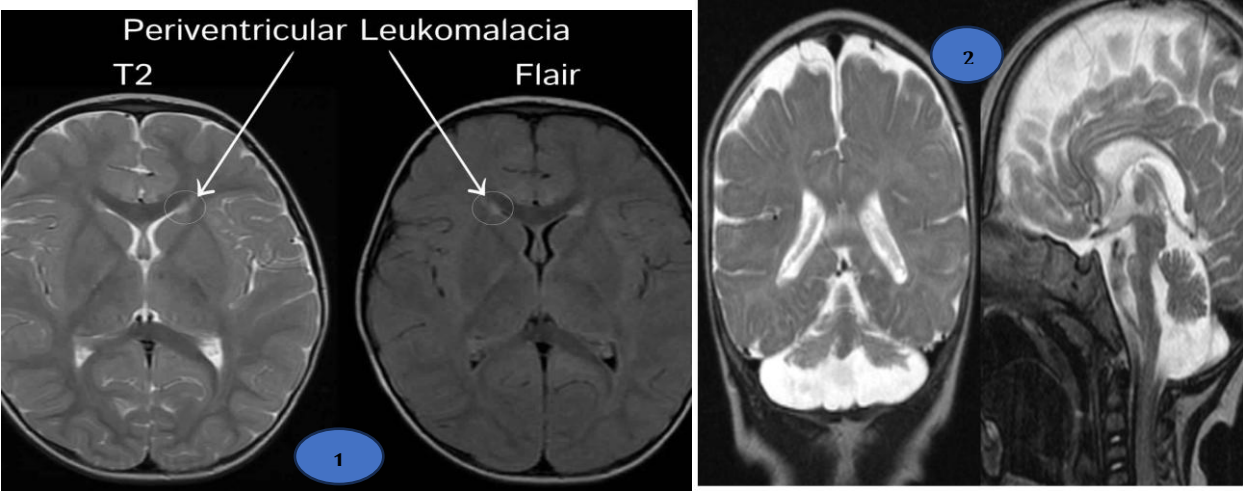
Hyperintense (bright) signals around the ventricles indicate white-matter injury; FLAIR distinctly highlights periventricular gliosis.
